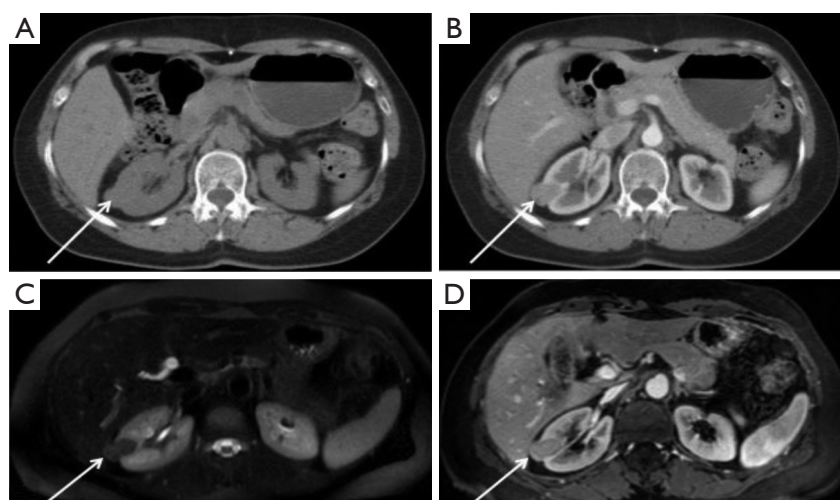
Patient No. 5. Transverse CT and MR scans in a patient with clear cell renal cell carcinoma. (A) Unenhanced CT image shows only the irregular profile of anterior region of the right kidney with no definite abnormality; (B) contrast-enhanced CT scan shows heterogeneous hyperenhancing by the lesion; (C) transverse fat-suppressed T2-weighted MR image shows heterogeneous signal hyperintensity by the lesion; (D) gadolinium-enhanced fat-suppressed T1-weighted MR image shows heterogeneous hyperenhancing by the lesion. CT, computed tomography; MR, magnetic resonance.
